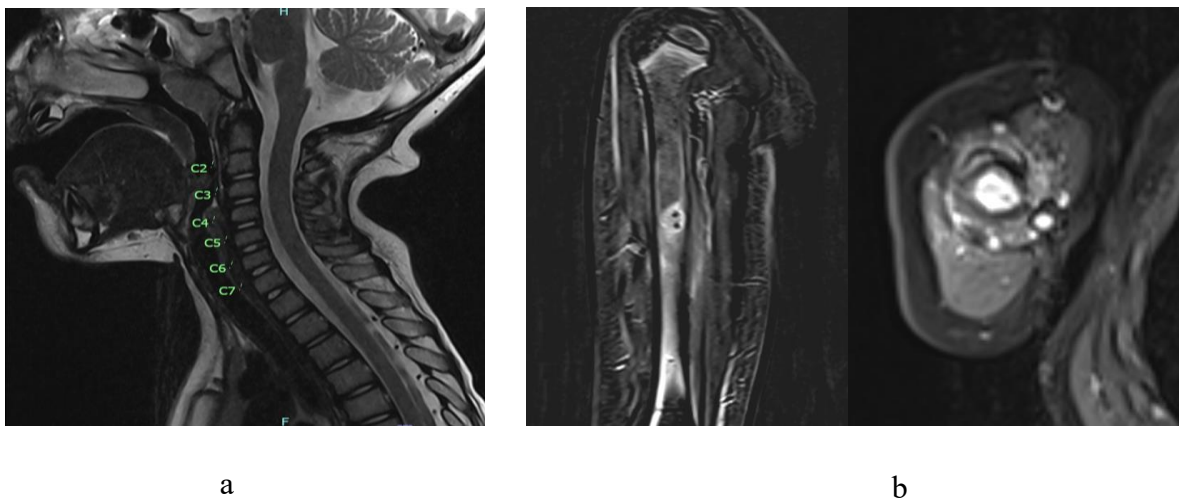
(a) MRI cervical spine including brachial plexus was normal. (b) MRI humerus showing enhancing lesion at midshaft of humerus
